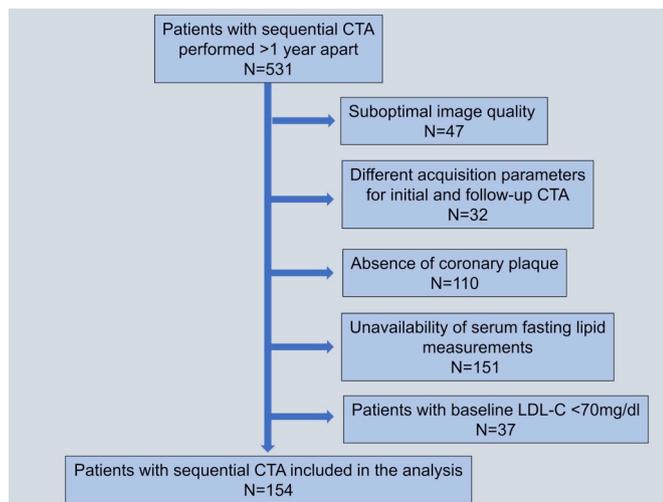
Selection of patients for coronary CTA analysis.
